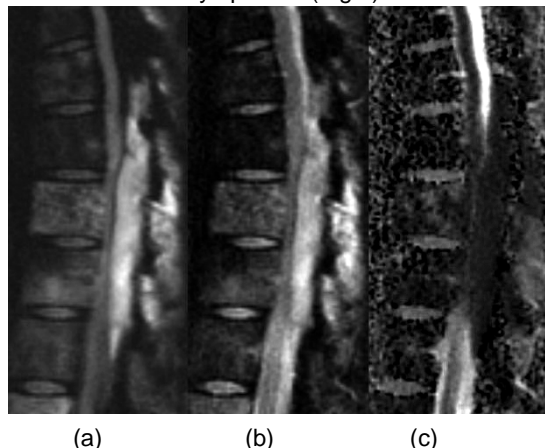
19 year old woman with back pain. rFOV (a) isotropic DWI, (b) T2-weighted, and (c) ADC map demonstrating a large dorsal epidural mass with reduced diffusion causing spinal cord compression. This was found to be lymphoma at surgical resection. Reduced diffusion is characteristic of small round blue cell tumors such as lymphoma, and narrowed the diagnostic possibilities in this case.
